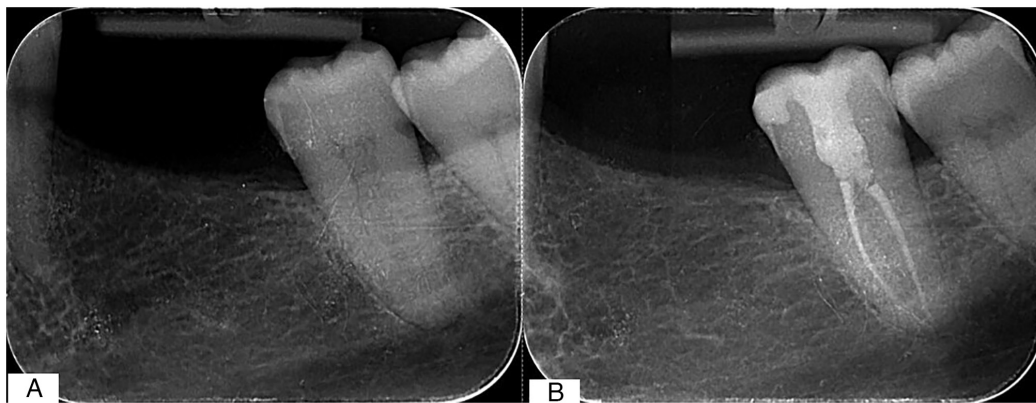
(A) Preoperative and (B) postoperative radiography of tooth 37 (lower left 2nd molar) filled with BioRoot RCS.
